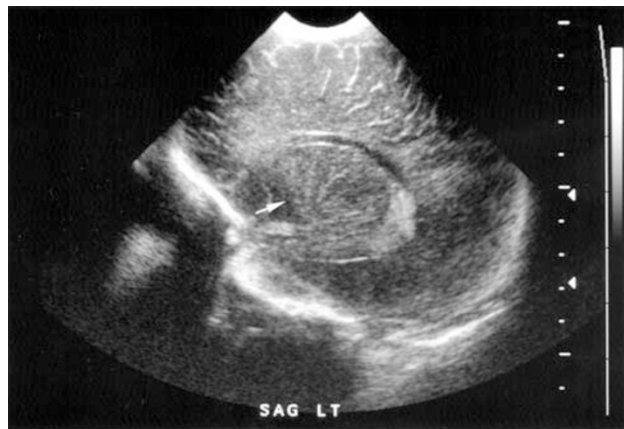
Sagittal head ultrasound of a 26-week premature infant with lenticulostriate vasculopathy.
